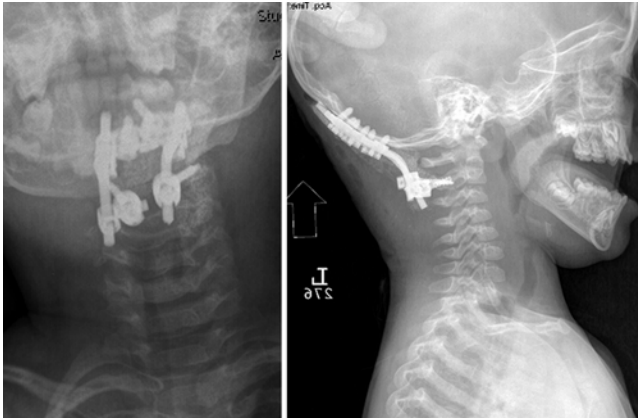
Anteroposterior (left) and lateral (right) radiographs showing an occipitocervical fusion in a 2-year-old girl involved in a motor vehicle accident with occipitoatlantal instability.
